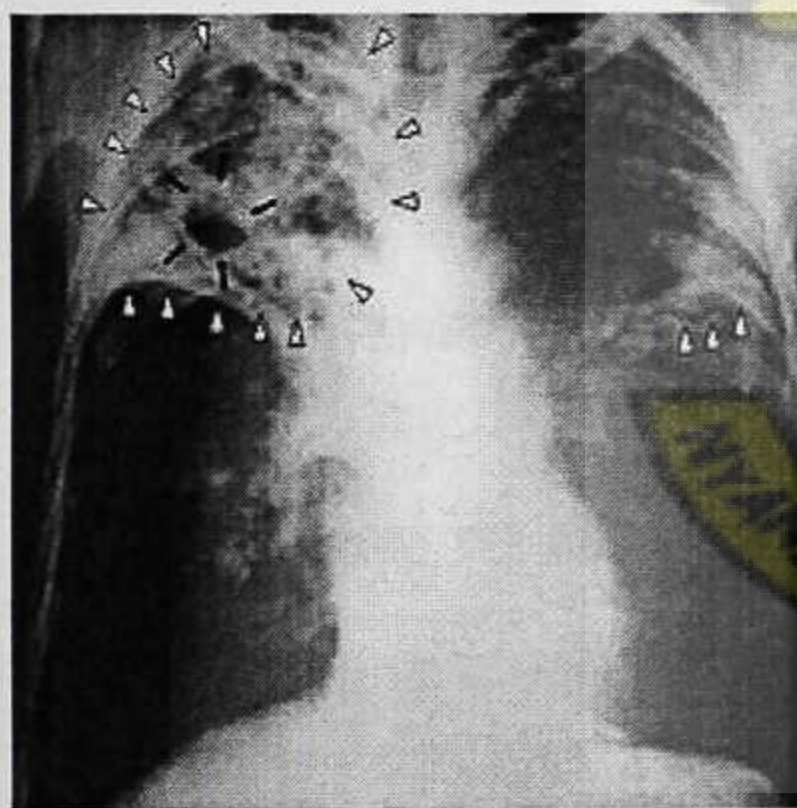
shows Chest X-ray of a person with advanced tuberculosis
